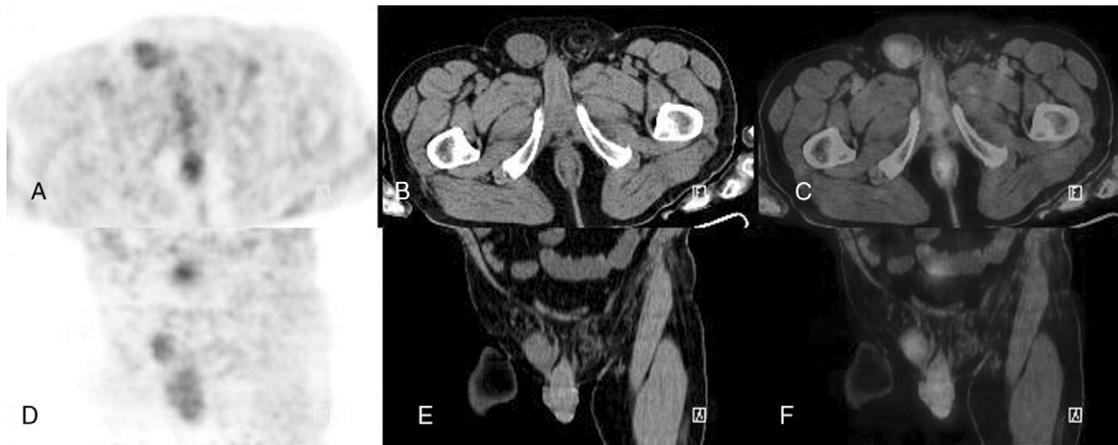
(A) Axial PET, (B) CT, and (C) PET/CT fusion images and (D) coronal PET scan, (E) CT scan and (F) PET/CT fusion confirmed this activity belonged to an undescended testis in inguinal canal. In our patient, the maximal standardized uptake value of the right undescended testis and left normal testis was 3.33 and 3.57, respectively. Although both maximal standardized uptake values were within normal limits in accordance with physiologic fluorodeoxyglucose uptake, undescended testes are known to have an increased risk of malignancy. On physical examination, a right testis was not found in the scrotum with palpation. No significant disorder was found from his history. The patient was referred to the urology department for surgical evaluation. In such cases, correlation with ultrasonography is recommended. No evidence of malignancy was found on ultrasonography. The CT component of PET/CT provided an advantage in the differential diagnosis of the inguinal region. CT findings has been useful in showing focal increased fluorodeoxyglucose uptake seen on PET imaging at right inguinal region belonging to undescended testicular activity.
